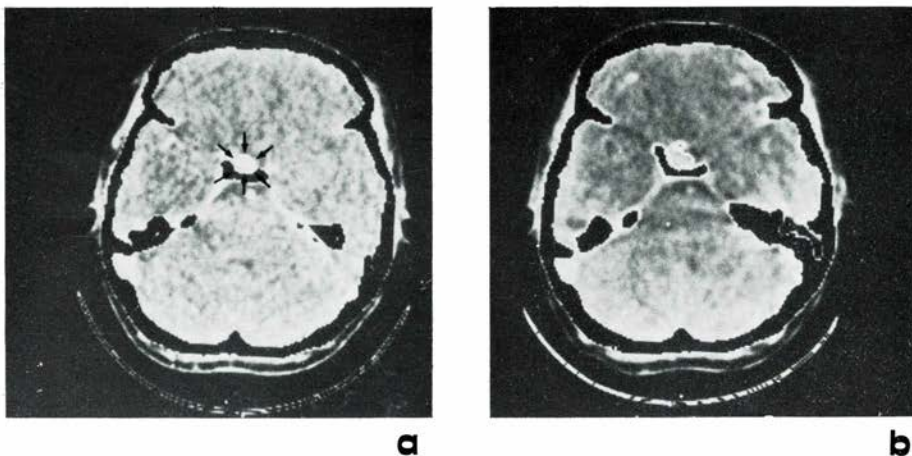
CT scan at sellar level before (a) and after (b) pregnancy: the tumor diameters are respectively 6×9 mm in «a» and 7×10 in «b».
